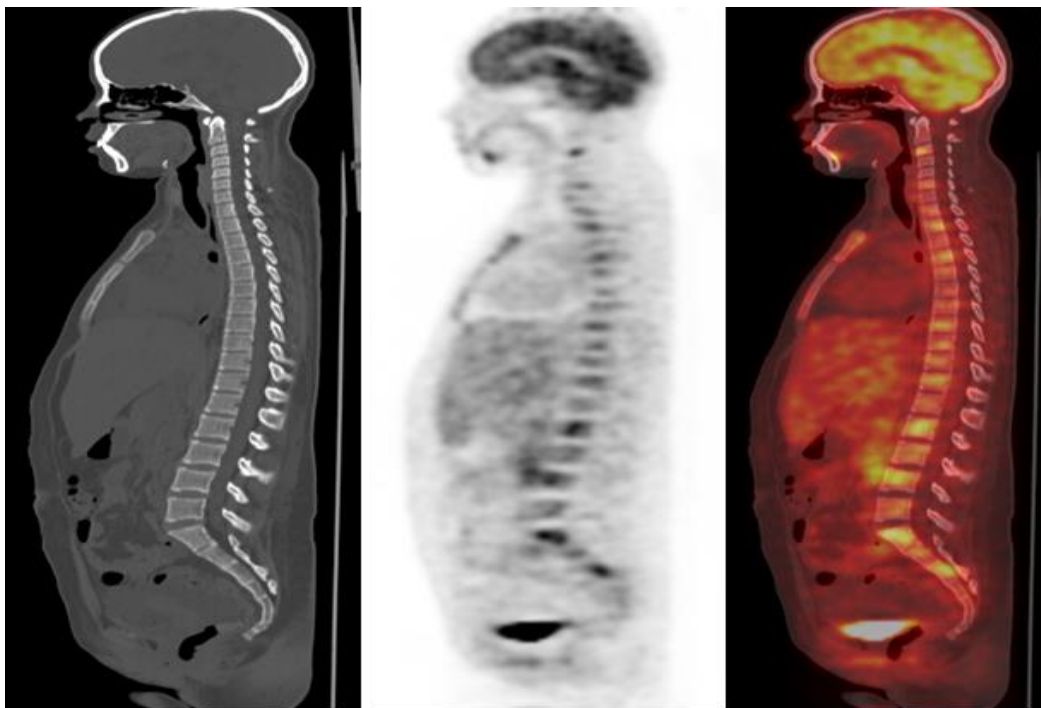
Initial pretreatment PET/CT revealed metabolically multiple active FDG avid lesions in bone marrow.
